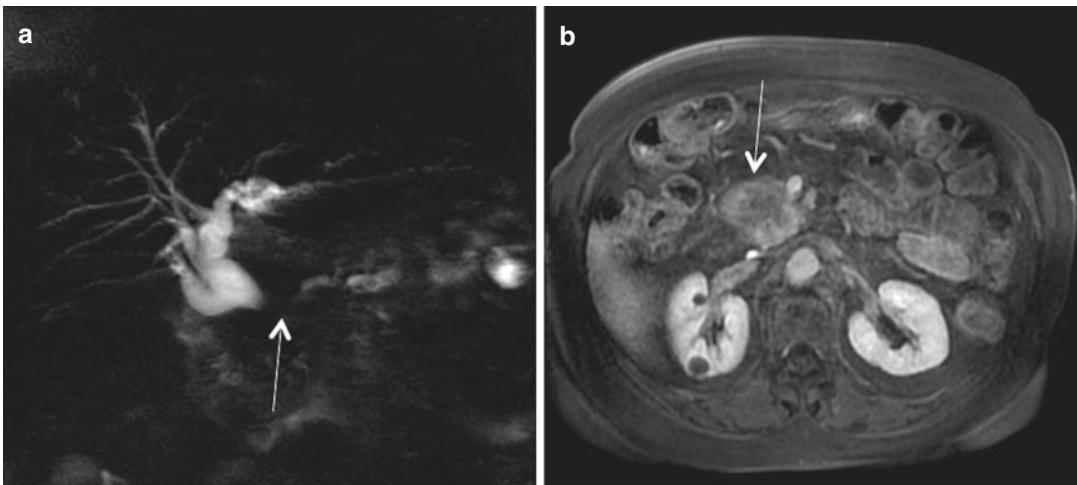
Adenocarcinoma of the head of the pancreas that appears on (a) 2D-MRCP with the “double duct sign” (*arrow*) and in (b) fat-suppressed T1-weighted image as
